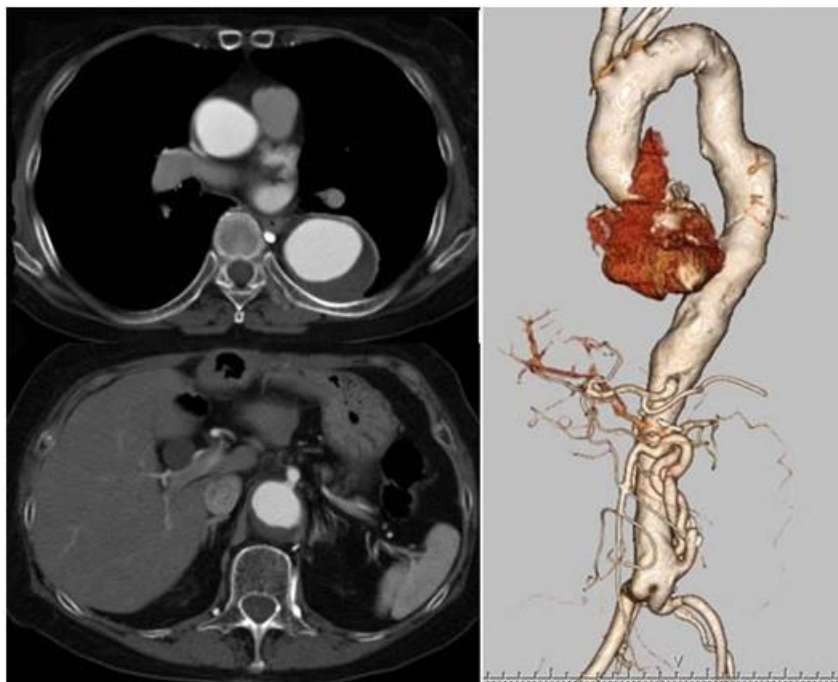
Enhanced computed tomography scan before TEVAR shows a large thoracoabdominal aneurysm and occlusion of a bypass graft to the celiac artery.
